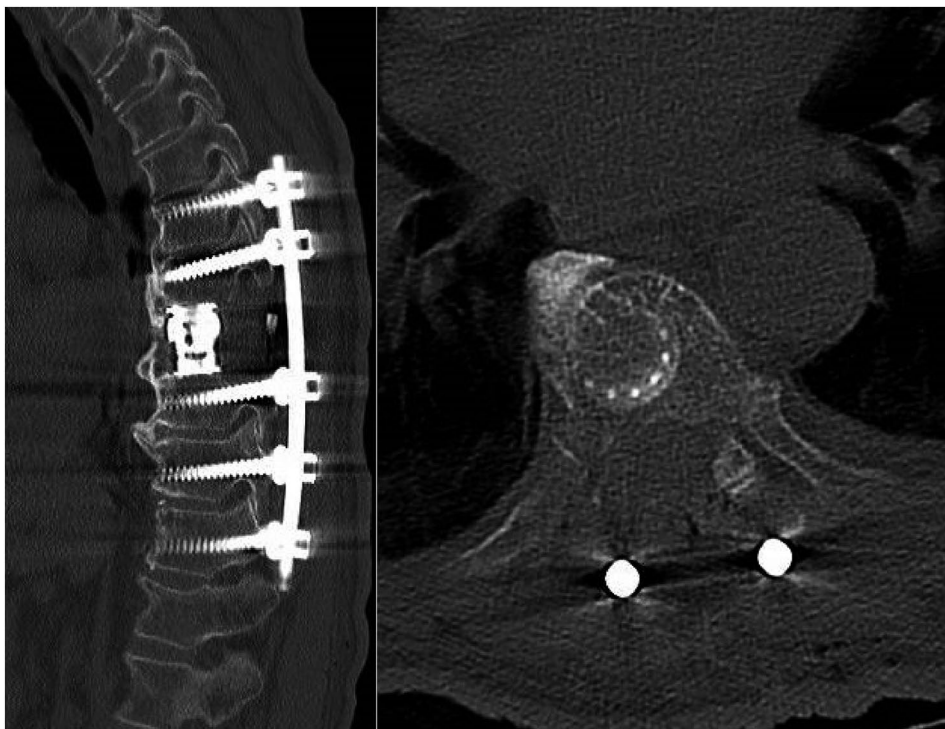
Sagittal (left) and axial (right) slices from the patient's post-operative CT scan demonstrating the sagittal anterior column reconstruction and intact costocentral articulation on the transpedicular approach side, respectively
